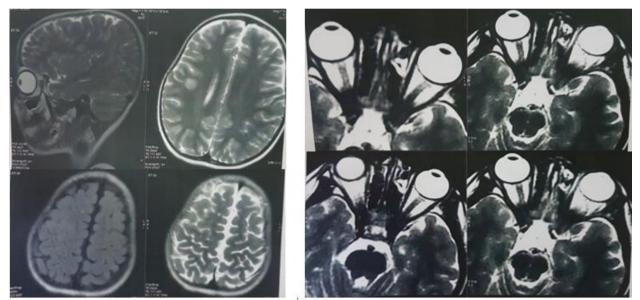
MRI showed bilateral optic neuritis, chronic plaque in right parietal lobe, right and left centrum semiovale according to multiple sclerosis.
